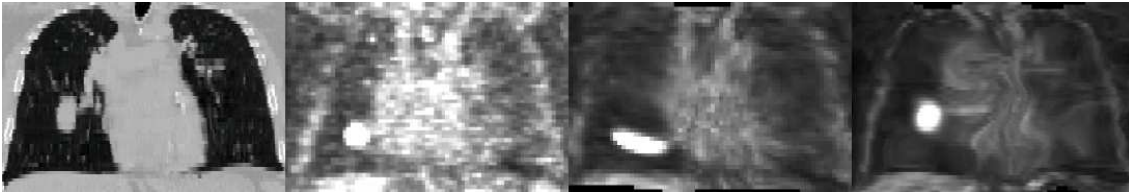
Improvement of the registration in the tumor area. From left to right: CT and PET original images; PET image registered without tumor constraints; PET image registered with tumor constraints.
